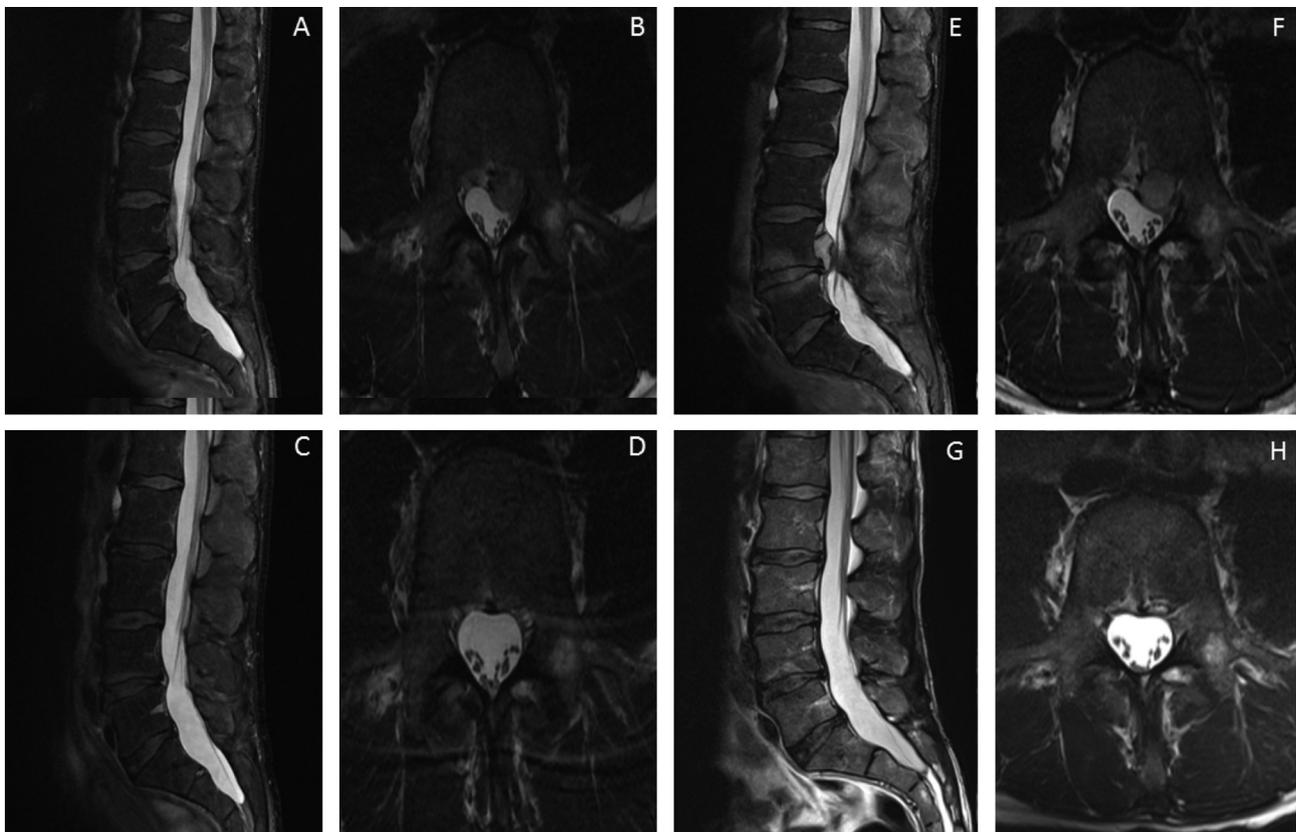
Initial MRI study (T2-weighted image) of the lumbar spine (A: sagittal, B: axial) revealed a large upwardly migrated sequester at the L4–L5 level compressing the dural sac and both left L4–L5 roots. Follow-up MRI study (T2-weighted image) (C: sagittal, D: axial) revealed spontaneous resorption of the disc fragment at L4–L5 after 4 months. One year later, the MRI (T2-weighted image) showed recurrence of (E: sagittal, F: axial) a left-sided large migrated sequester at the L4–L5 level. Just before the scheduled surgery, the MRI (T2-weighted image) (G: sagittal, H: axial) showed second complete disappearance of the discal fragment.
